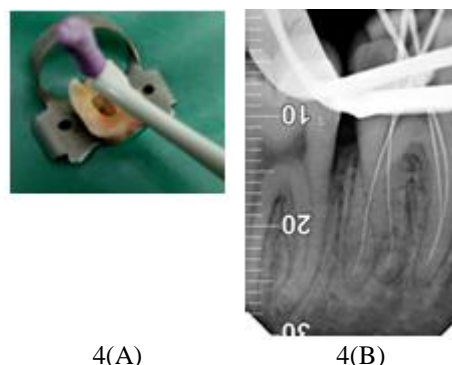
Working length determination with electronic root length measuring device (A) and confirmed with radiographic method (B)
